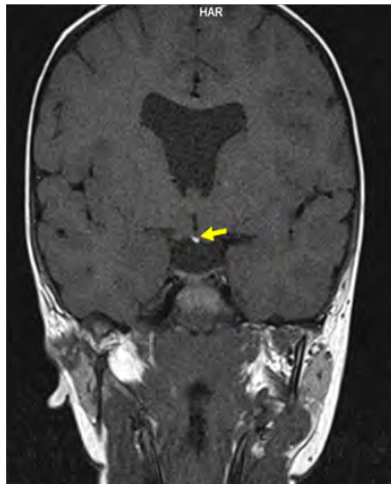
T1 weighted MRI brain plain (Coronal section) of case 1 showing hypoplastic anterior pituitary, absent septum pellucidum and stalk and ectopic posterior pituitary (arrow head).
